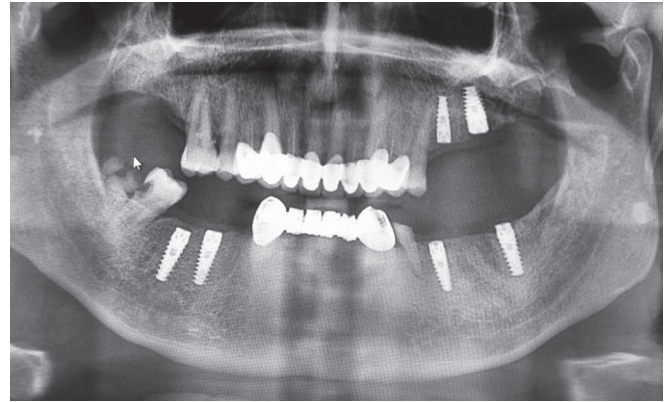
Postoperative orthopantomogram after retrieval of implant
